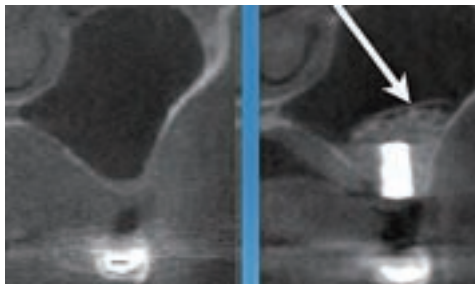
Case 5 postsurgical CT image. Note excellent lateral bone condensation and resorbable membrane (arrow).
